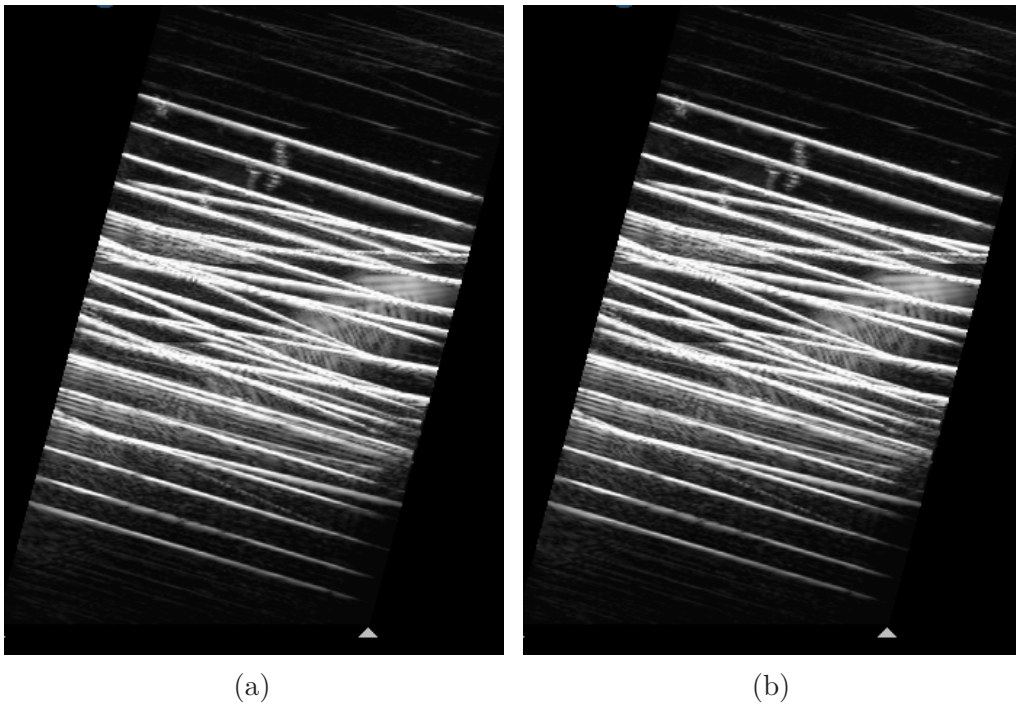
The two ultrasound images of hair.
